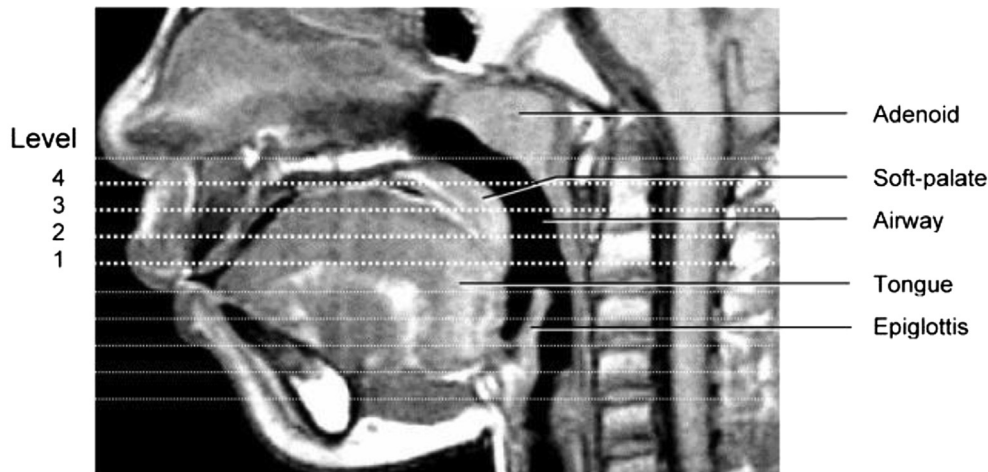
UA imaging by MRI. Reprinted with permission of the American Thoracic Society. Copyright © 2014 American Thoracic Society [64].
